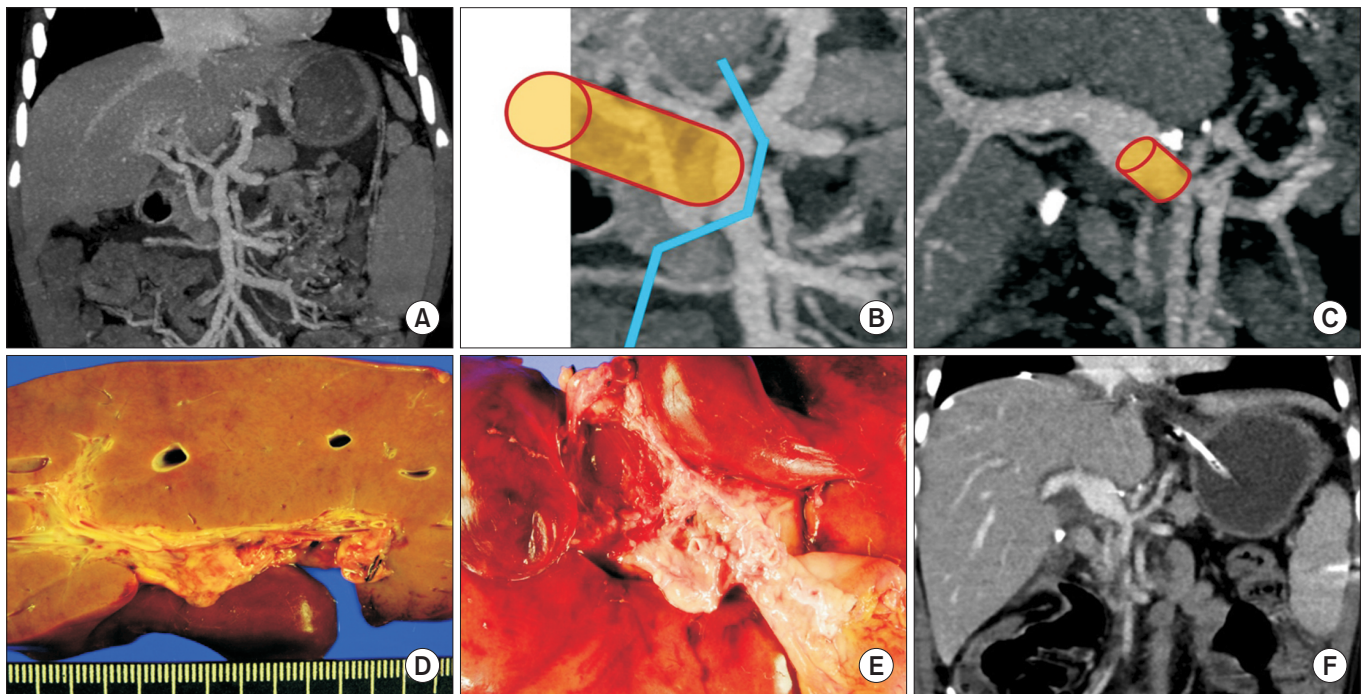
Image summary of the deceased donor liver transplantation case. (A) Pretransplant computed tomography (CT) showed agenesis of the portal vein with cavernous transformation and secondary portal hypertension, accompanied by gastric and esophageal varices. (B) An external iliac vein graft (cylinder) was anastomosed to the superior mesenteric-splenic vein confluence after deep clamping of this site (blue line). (C) The interposed vascular conduit (cylinder) was positioned between the superior mesenteric-splenic vein confluence and the graft portal vein. (D) Gross photograph of the explanted liver showed non-cirrhotic parenchyma. (E) Magnified view of the portal triad area demonstrated increased vascularity, variable portal venous structures, and intimal fibrosis. (F) Posttransplant CT obtained 7 days later showed smooth, streamlined portal vein reconstruction with resolution of variceal collaterals. Reproduced from Namgoong et al. Korean J Transplant 2021;35:59–65. [11]
